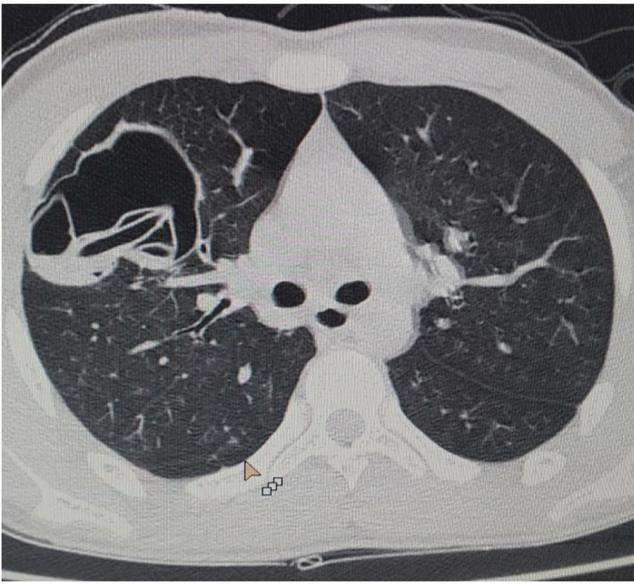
Post-aspiration CT thorax showing the dancing hand sign.
